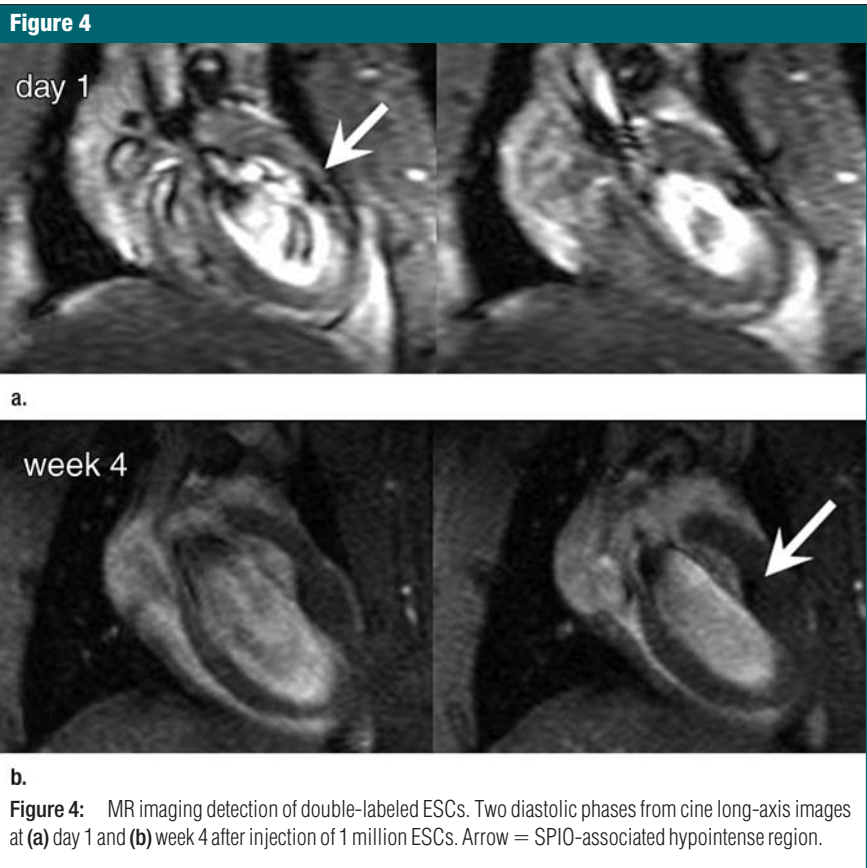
MR imaging detection of double-labeled ESCs. Two diastolic phases from cine long-axis images at (a) day 1 and (b) week 4 after injection of 1 million ESCs. Arrow = SPIO-associated hypointense region.
